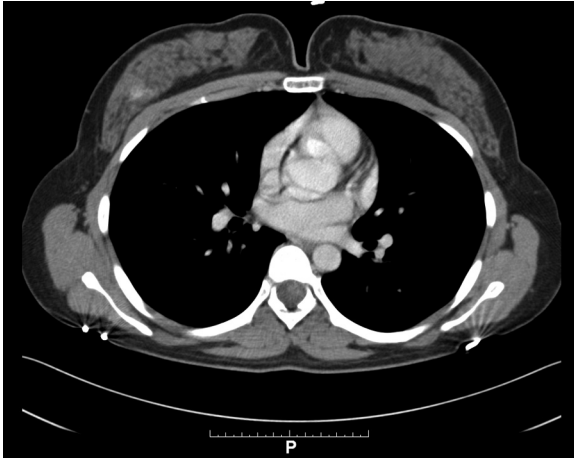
Axial postcontrast CT of the chest (in two contrast windows) demonstrates a poorly defined area of enhancement in the upper outer quadrant of the right breast. CT, computed tomography.
